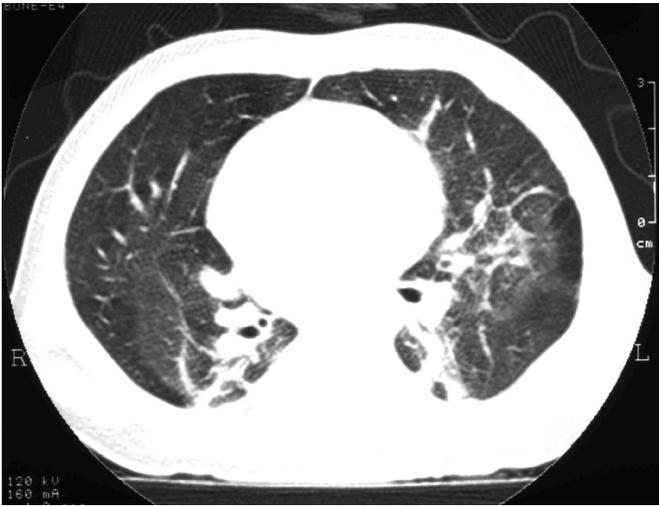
Initial and follow-up plain chest radiographs and HRCTs of a premature baby.
